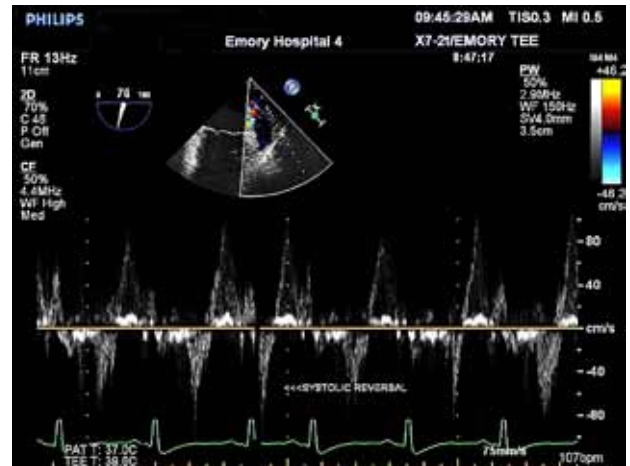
Transesophageal echocardiography, Doppler image showing systolic flow reversal in the left upper pulmonary vein.
